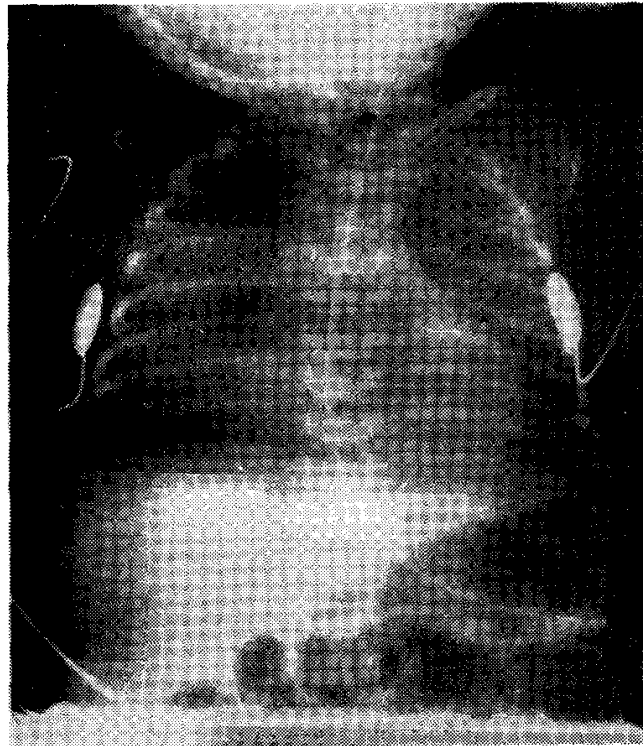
X-ray chest of a 7-day-old infant with PDA showing cardiomegaly and straight line sign.
